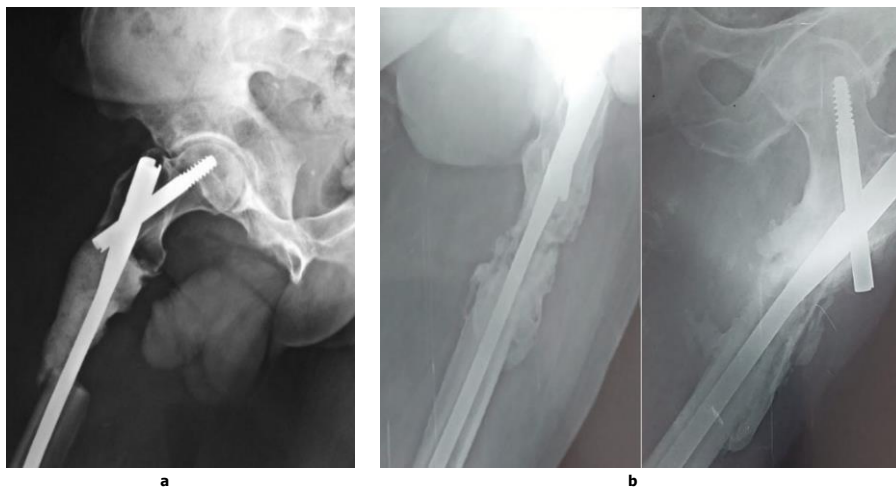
post-operative follow-up X-rays
